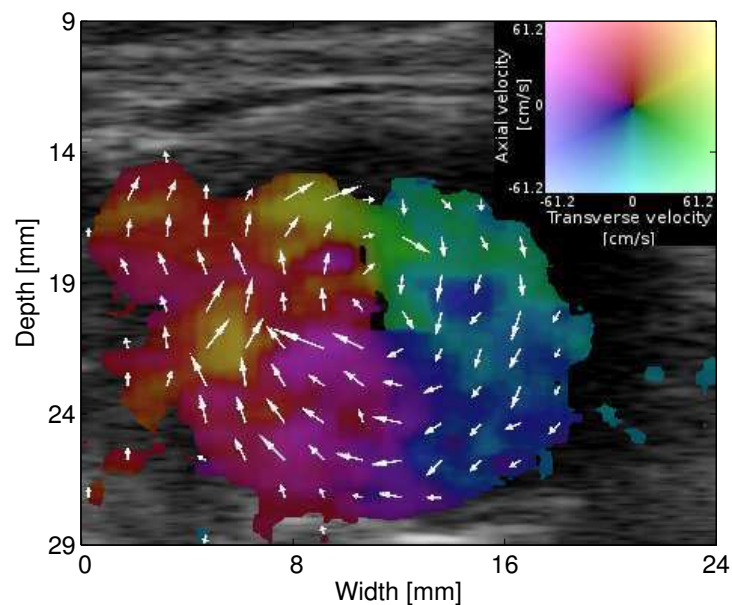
Vector flow ultrasound of the abdominal aorta in the cross-sectional plane. The flow pattern is visualized by the colors and the white vectors providing the magnitude (length) and angle (direction) of the flow.*
